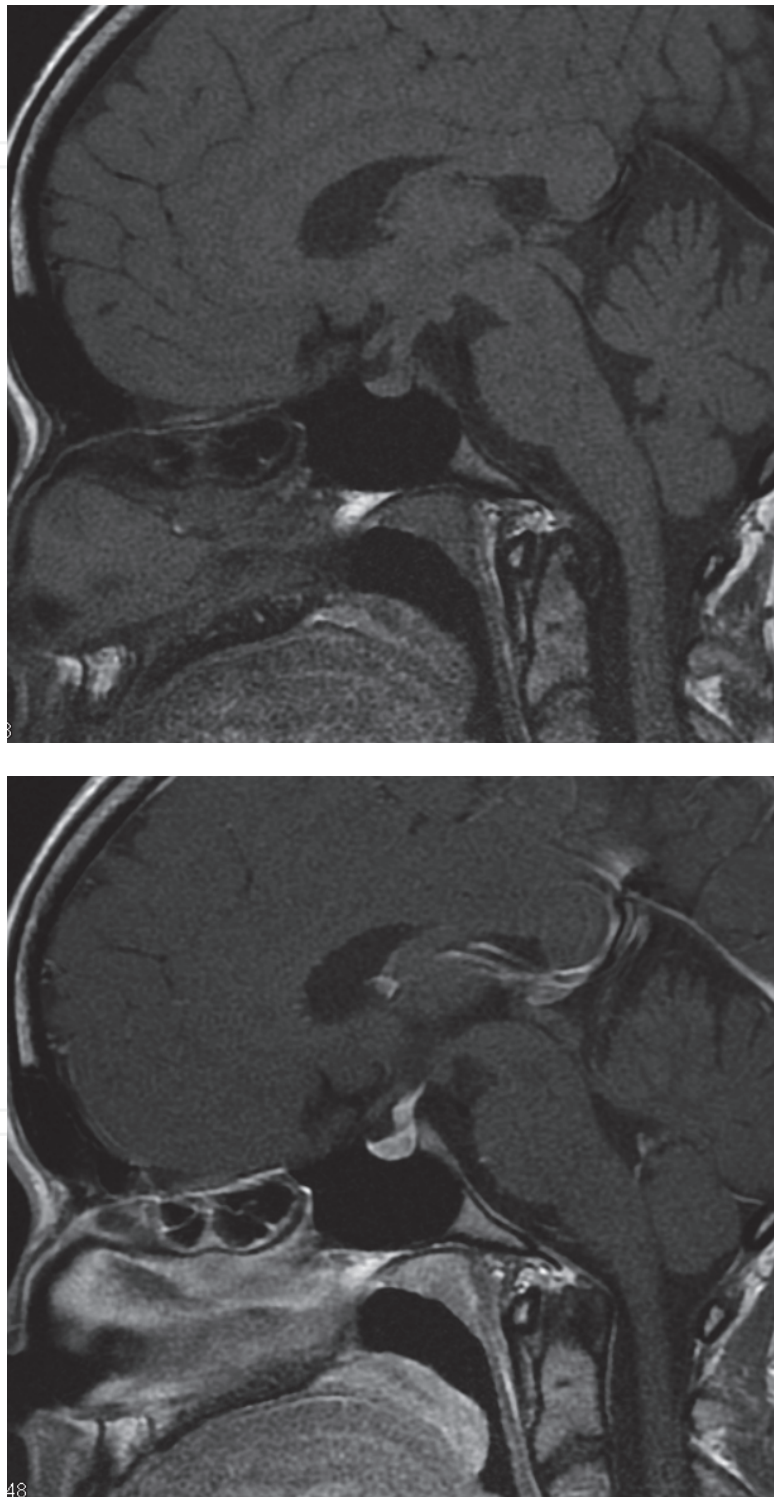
Histiocytosis involving the pituitary infundibulum. Sagittal non contrast T1W MR image (top) shows absent posterior pituitary bright spot with thickened enhancing pituitary infundibulum on post contrast T1W sagittal MR image (bottom).
